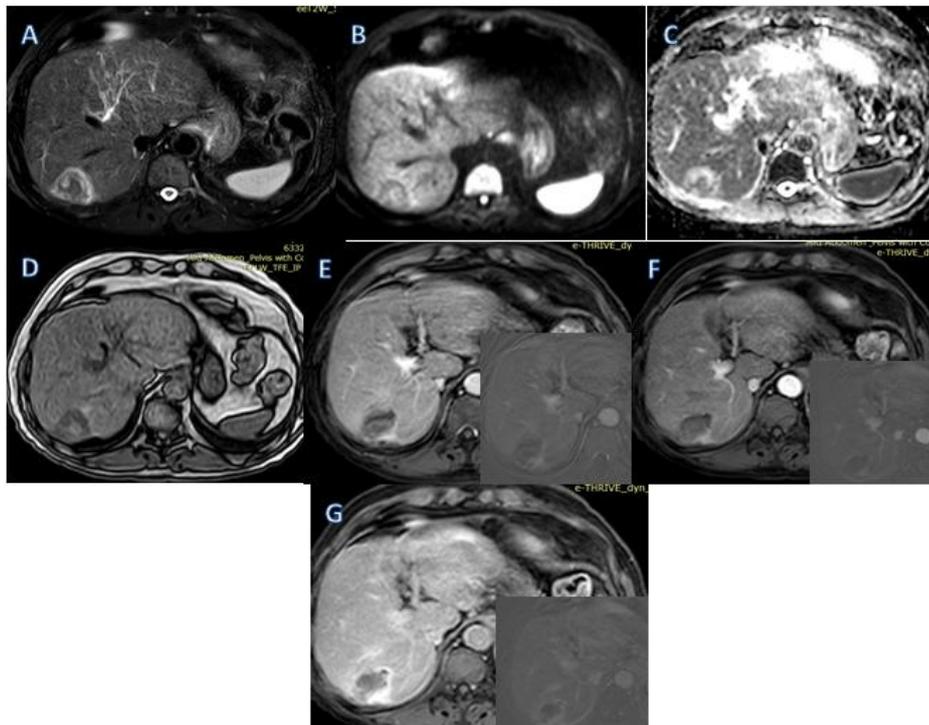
Figures from A to H showing cirrhotic liver with segment VI/VII ablated HCC showing residual/recurrent tumoral tissue. A: T2 STIR WI of post TACE HFL showing heterogenous signal intensity with central low area. B: DWI eliciting heterogenous signal of the HFL. C: ADC eliciting heterogenous signal of the HFL and ADC value 967×10^{-3} at lowest area. D: T1 WI out of phase eliciting heterogenous signal of the HFL with central high area. E: Coronal T2 WI. F to H: Post contrast dynamic images in late arterial (E), Venous (F) and delayed (G) phases with subtraction images showing posterior basal peripheral nodular contrast enhancement.
